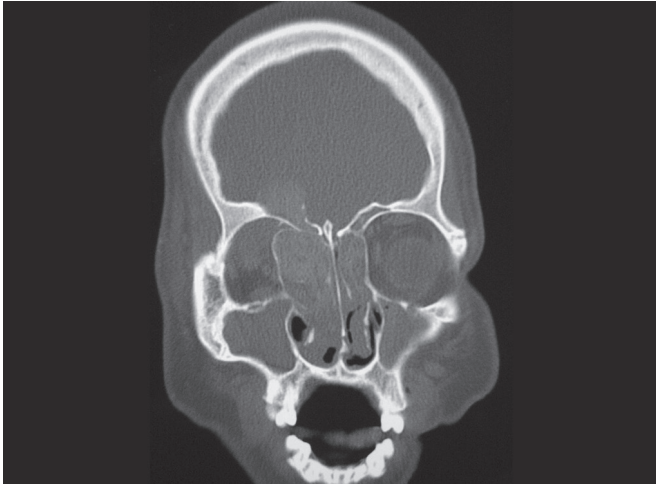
Coronal image from a computed tomography scan of a patient with allergic fungal rhinosinusitis. The imaging demonstrates extensive heterogeneous opacification of multiple sinuses and significant remodeling of the right lamina papyracea with resulting mass effect on the right orbital contents.
